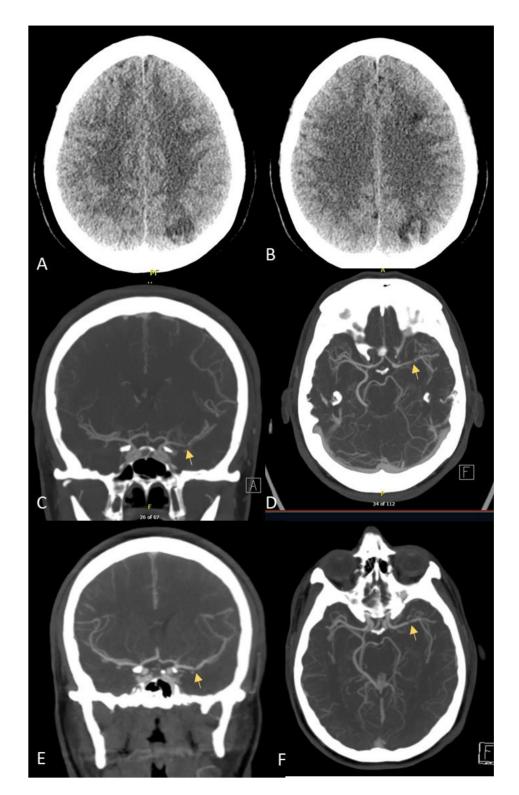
Axial non-contrast CT head (A and B) showing hypodensities in the left posterior parietal lobe with hemorrhagic transformation and left frontal lobe. Coronal and axial CT angiograms (C and D) on initial presentation showing focal moderate to severe stenosis of the left M1 of the middle cerebral artery (MCA) and 86 days later (E and F) showing moderate stenosis of left M1 (improved from initial image, yellow arrows) (Color version of the figure is available online.)
